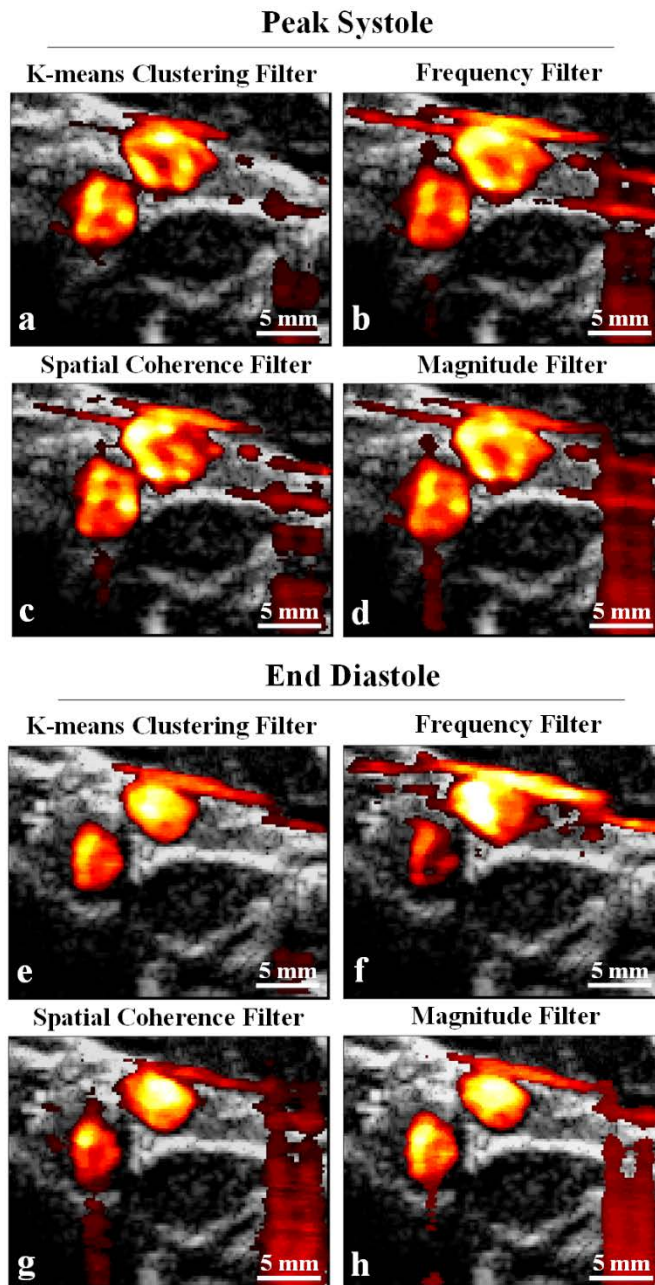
Improved flow detection and noise suppression achieved using (a), (e) K-means based SVD filter in comparison with (b), (f) Frequency based filter, (c), (g) Spatial Coherence based filter, and (d), (h) Magnitude based filter. Post-filtered power Doppler maps overlaid on the CCA and JV cross-sectional B-mode image are shown at (a)-(d) peak systole and (e)-(h) end diastole phase of the cardiac cycle. Dynamic range was kept the same for all the images at 26 dB.
